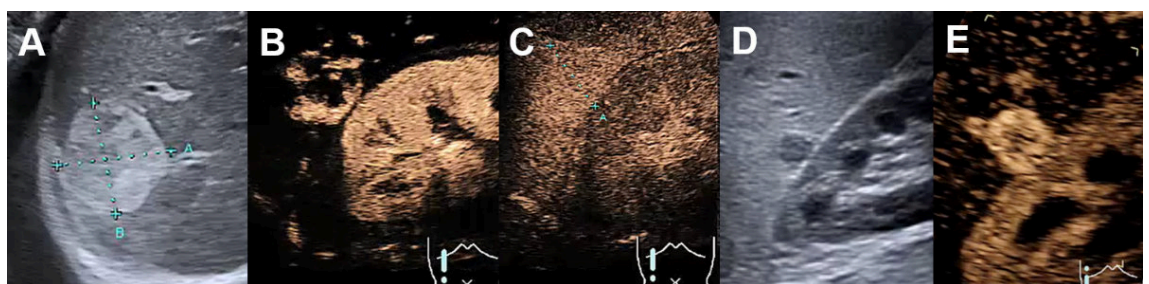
Haemangioma on conventional ultrasound and CEUS. A Hyperechogenic haemangioma on ultrasound, B with centripetal contrast enhancement on CEUS in the arterial phase, C with complete contrast enhancement and without wash-out in the late venous phase. D Hypoechoic hemangioma next to the kidney on ultrasound. E Complete contrast enhancement on CEUS in the arterial phase.
